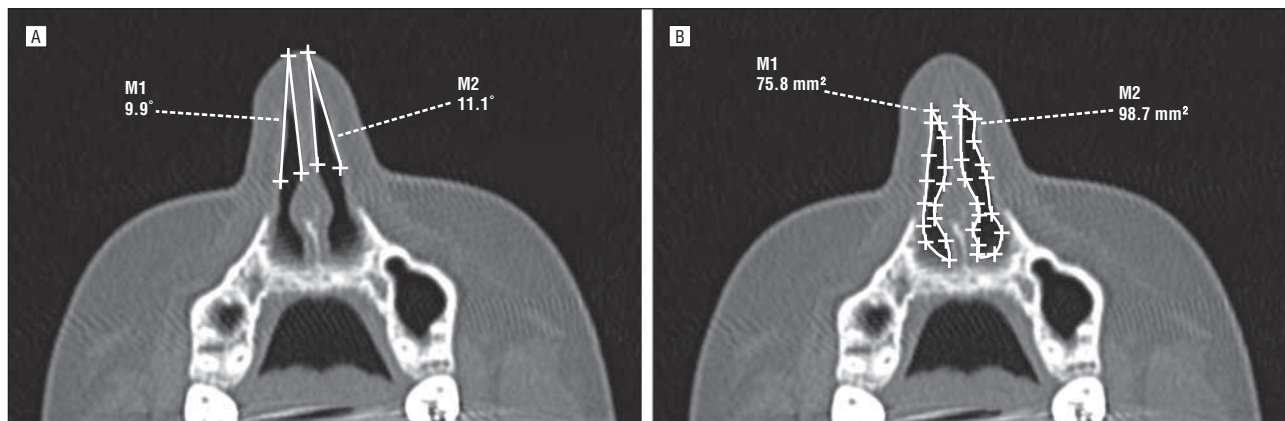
Reformatted computed tomograms of the internal nasal valve region. A, Measurement of the internal nasal valve angle in the same patient but now oriented according to the reformatted plane. B, Measurement of the cross-sectional area of the internal nasal valve region in the same patient now oriented in the reformatted plane. Abbreviations are defined in the legend to Figure 1.
